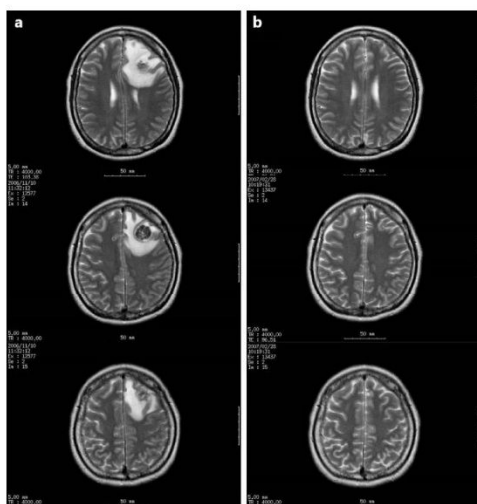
MRI in November 2006 showed recurrent brain metastasis approximately 20 mm in diameter in the left frontal lobe (a). MRI in February 2007 showed that GKS was effective in controlling the lesion (b).
